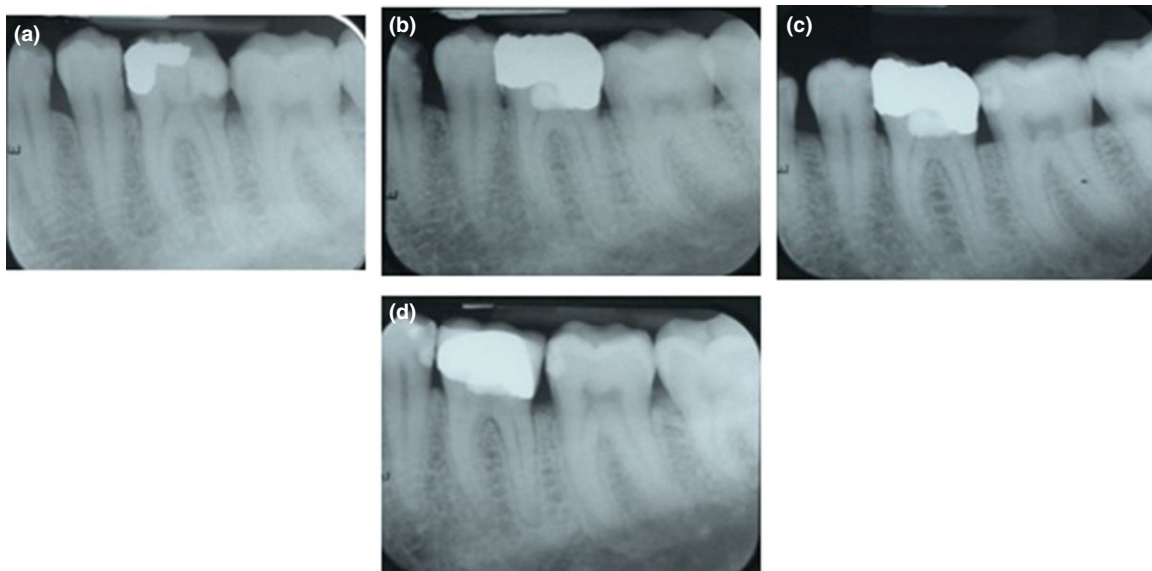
Radiographs of 36-year-old male patient with signs and symptoms clinically suggestive of irreversible pulpitis and widening of the periodontal ligament space in tooth 36. (a) preoperative radiograph, (b) Immediate postoperative radiograph, (c) 3-year recall, (d) 4-year recall: the tooth is asymptomatic with normal periapex and hard tissue barrier formation in the distal canal below the MTA with concomitant narrowing and calcification of the mesial canals. The tooth has a metal ceramic crown restoration.
